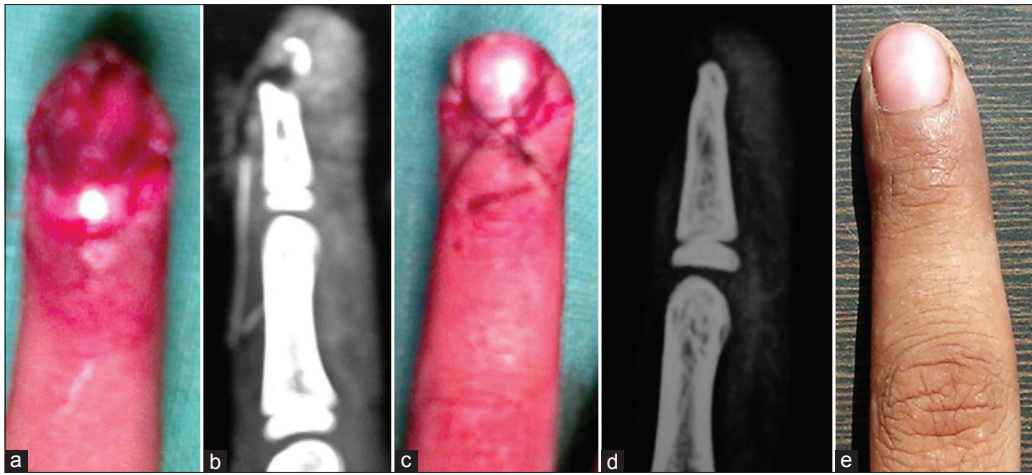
Clinical photographs (a,c,e) and x-rays lateral view (b,d) shows (a) An 8-year-old male child with injury through the proximal nail plate. (b) Fracture of the tuft of distal phalanx with volar displacement. (c) Dorsal vertical figure-of-eight suture maintaining the repositioned nail plate and the fractured fragments. (d) Radiological evidence of healed fracture of distal phalanx. (e) Clinically stable fingertip at 1 year followup
